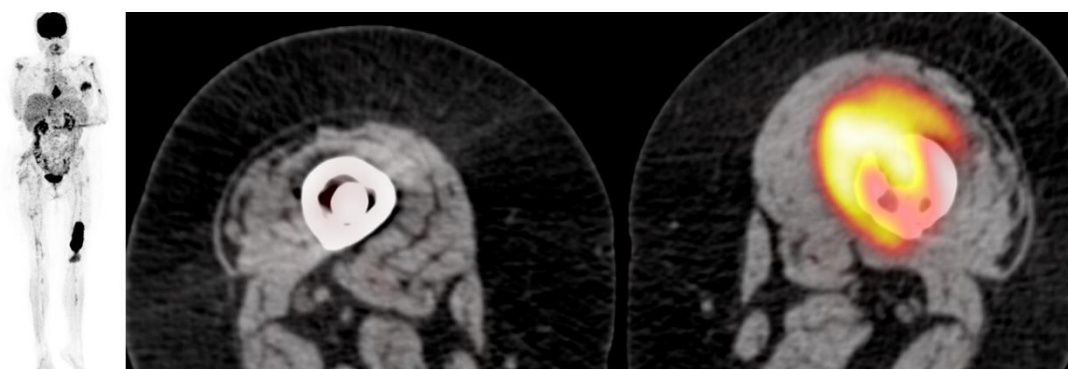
The patient presented with progressive right distal femoral lesion as well as thoracic plasmocytoma; multiple intensity projection and transaxial fusion PET/CT images of a female patient at 53 years of age
